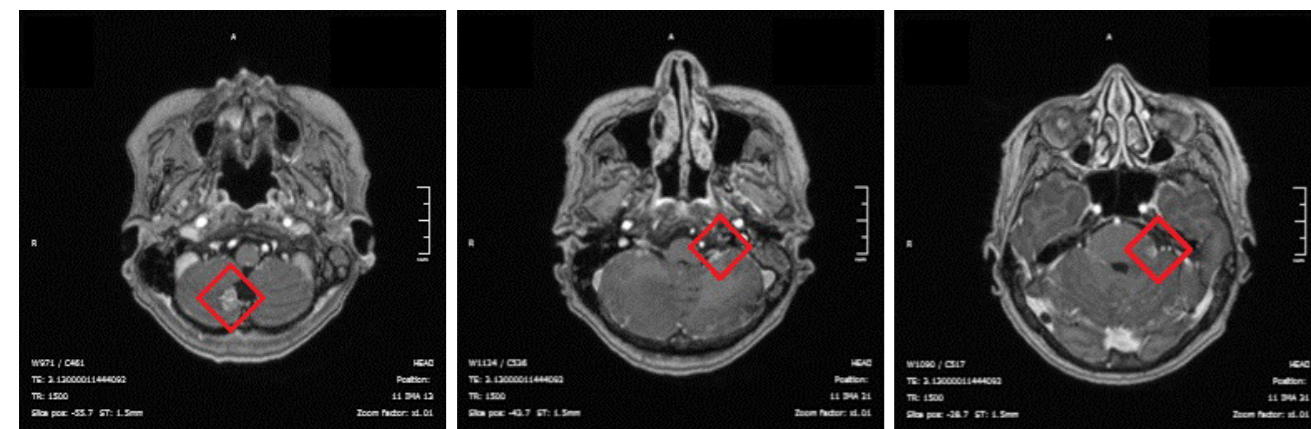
MRI scans showing three brain metastases in the cerebellum. Lesion 1 - left. Lesion 2 - middle. Lesion 3 - right.
